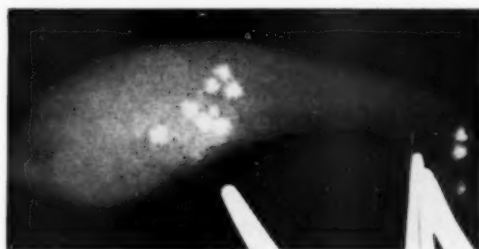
Roentgenogram of the excised gallbladder, showing calculi and opaque gallbladder contents.
